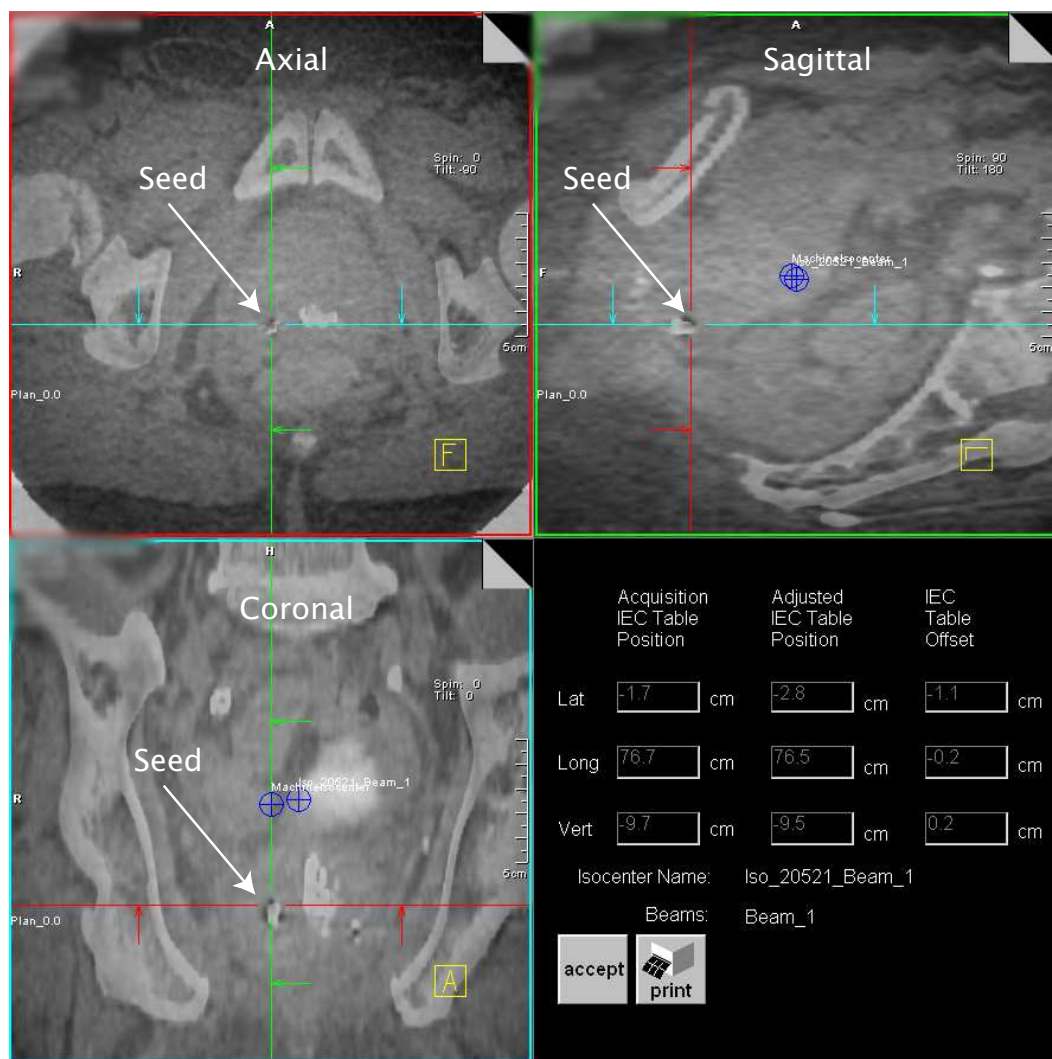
Example of prostate patient alignment using gold markers. The CT image is displayed in grayscale color map (seeds shown in white) while the MVCBCT image is displayed using an inverse grayscale color map with the seeds shown in black. Using a 50% CT, 50% MVCBCT transparency level, the gold seeds visualized in the axial, sagittal and coronal planes can easily be superimposed with each other in a combined displays. Gold markers can easily be identified on MVCBCT using only 2 MU of patient exposure.
